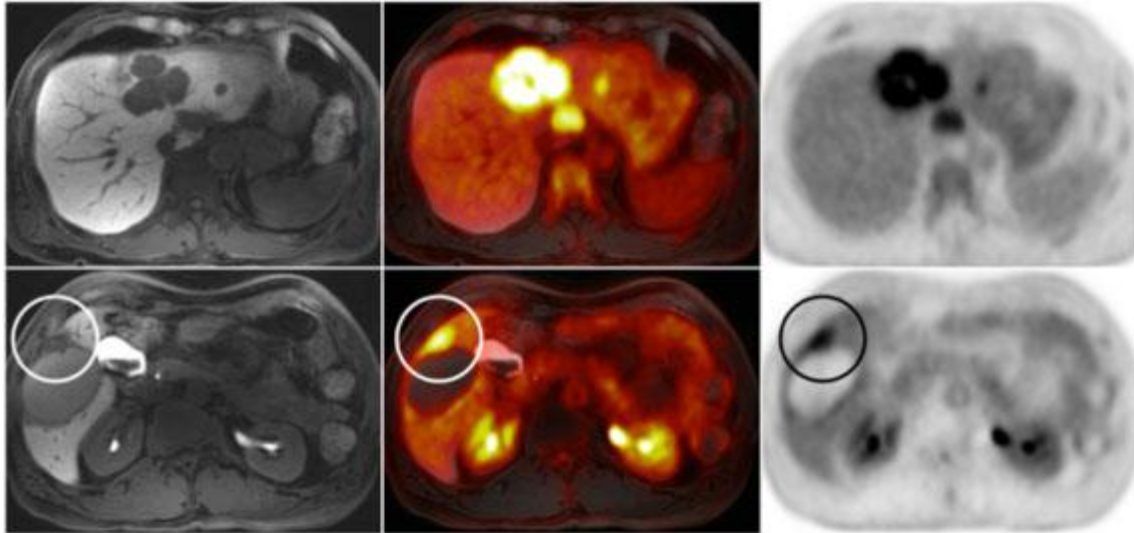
combined PET/MRI using FDG for staging of a patient with liver metastasis. In the right lobe of the liver there is a large treatment site seen on MRI (left column), but only when combining the information from the PET (right column) is it clear that there is viable tumor along the treatment site (circle).
